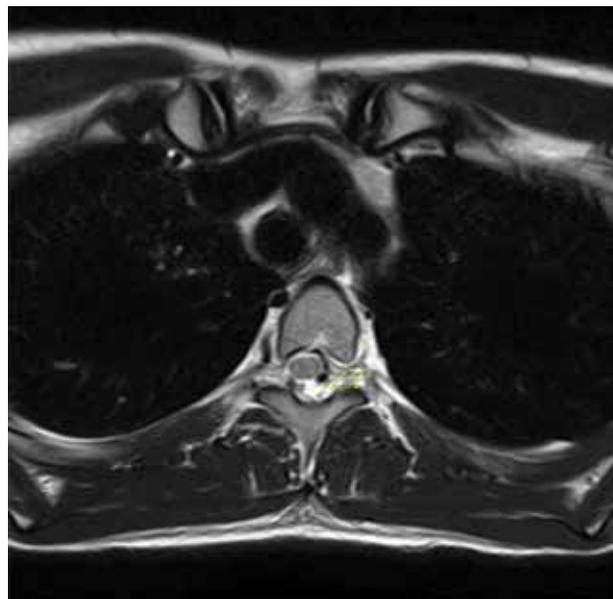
Axial T2 weighted MRI image showing CSF leak at the level of the T4 vertebrae.
